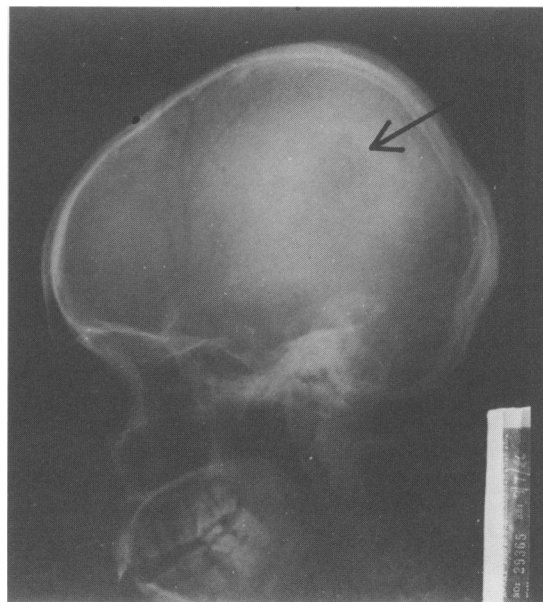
Skull X-ray showing irregular lytic lesions in right parietal region.
